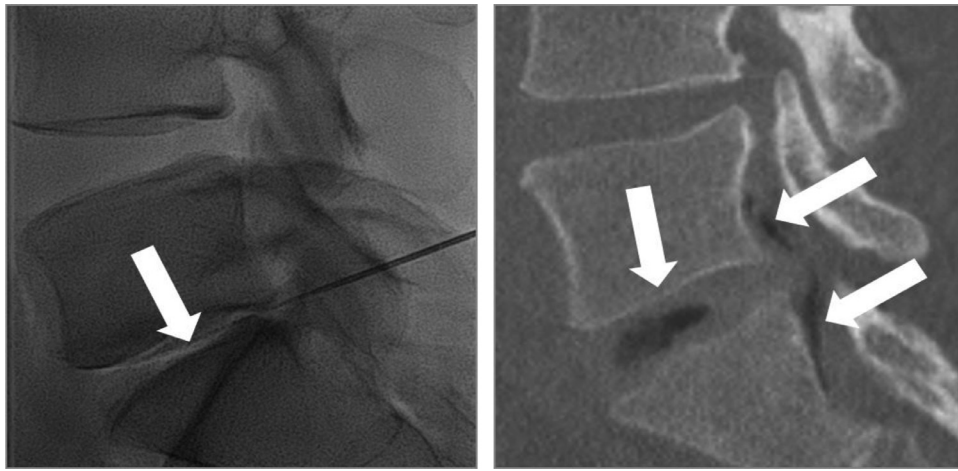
Intraoperative fluoroscopic images showing placement of the spinal needle and post-operative CT imaging shows gas has been injected into the nucleus pulposus with some spread to the anterior epidural space via an annular tear.
